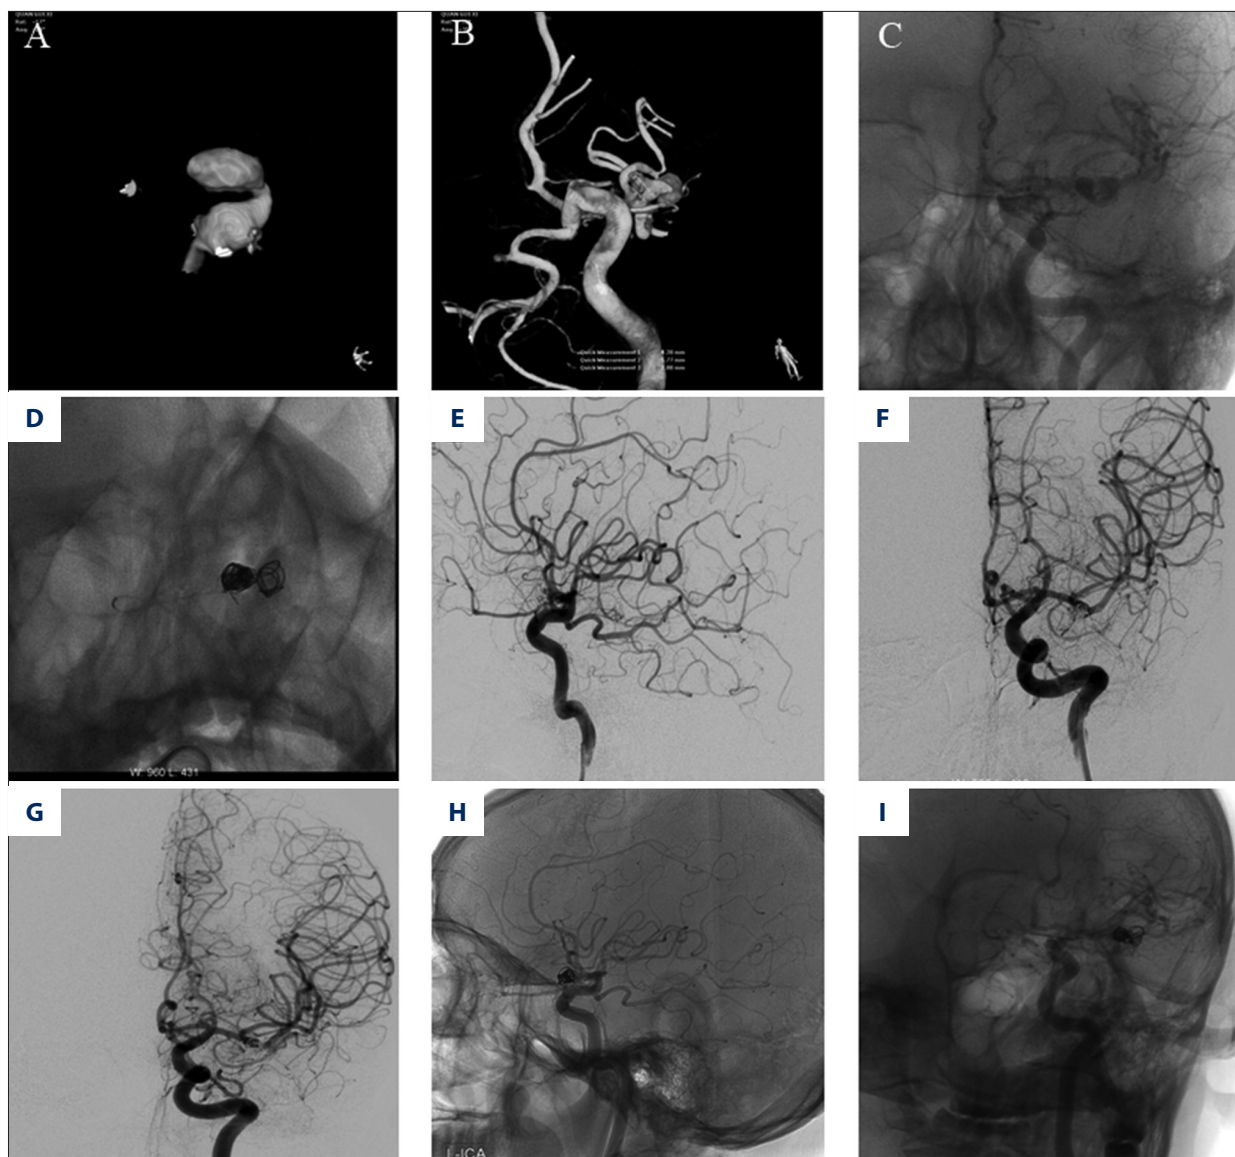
A 41-year-old male complaining of sudden-onset headache showed SAH on head CT scan. (A–C) Cerebral DSA revealed an irregular-shaped RICABF involving the middle cerebral artery. (D–F) The true aneurysm cavity was complete occluded and the distal sac was loosely occluded. The immediate angiography after embolization showed the complete occlusion of the aneurysm. (G–I) Follow-up angiography 19 months after the operation showed no residual or recurrent aneurysm.
